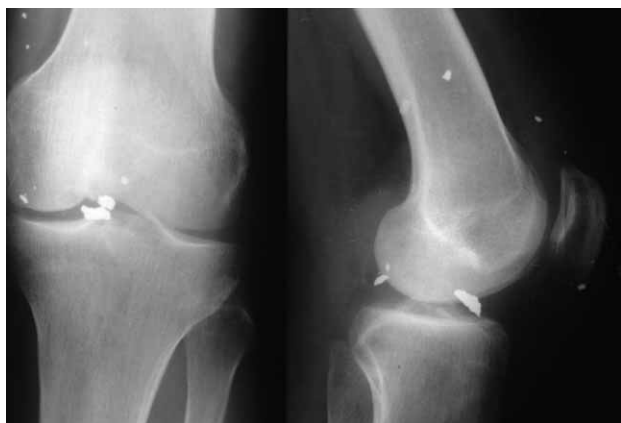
a) Anteroposterior and b) lateral radiographs of the knee joint with anchored metallic foreign body in the bone.
